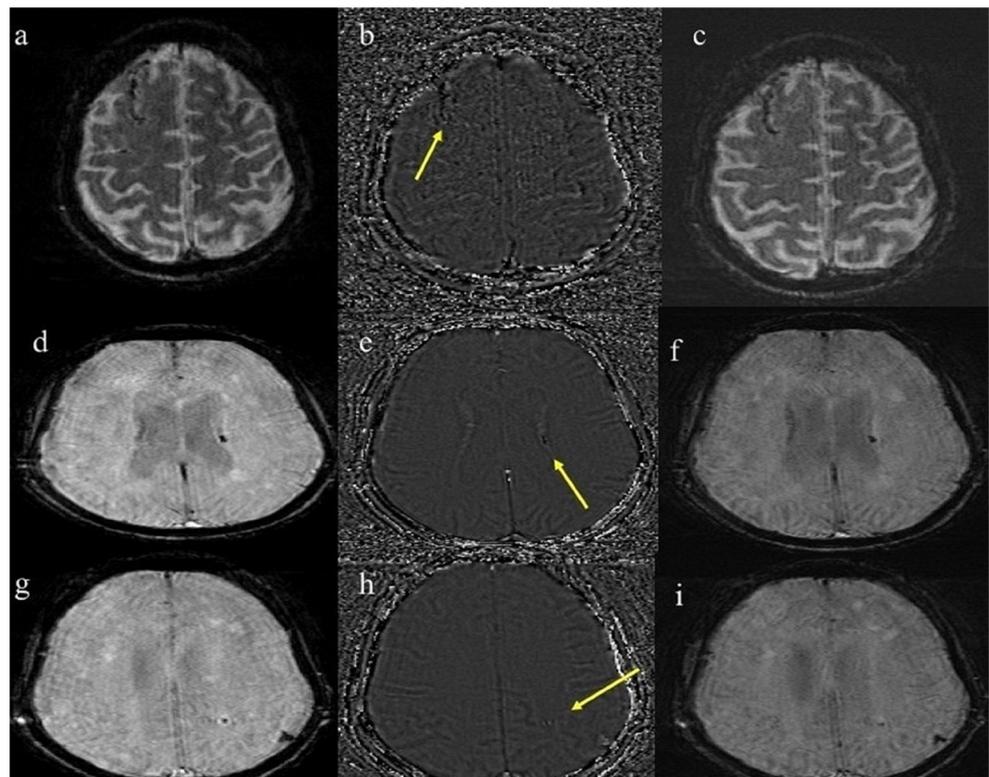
In these figures, SWI images with magnitude image (first image), phase-filtered images (second image) and SWI (third image) in each line is described. The right frontal sulcus appeared dark on magnitude (a) and SWI image (c) with negative shift (b) on the phase image. The SWI highlighted the other two areas that were not visible on CT scan in the left caudate body and in the periventricular white matter with the same characteristics. Magnitude image (d) and SWI image (f) in the left caudate body with negative shift (e) and magnitude image (g), SWI image (i) and phase image (h) in the left periventricular white matter. Yellow arrows indicate the corresponded negative shift in the phase image
